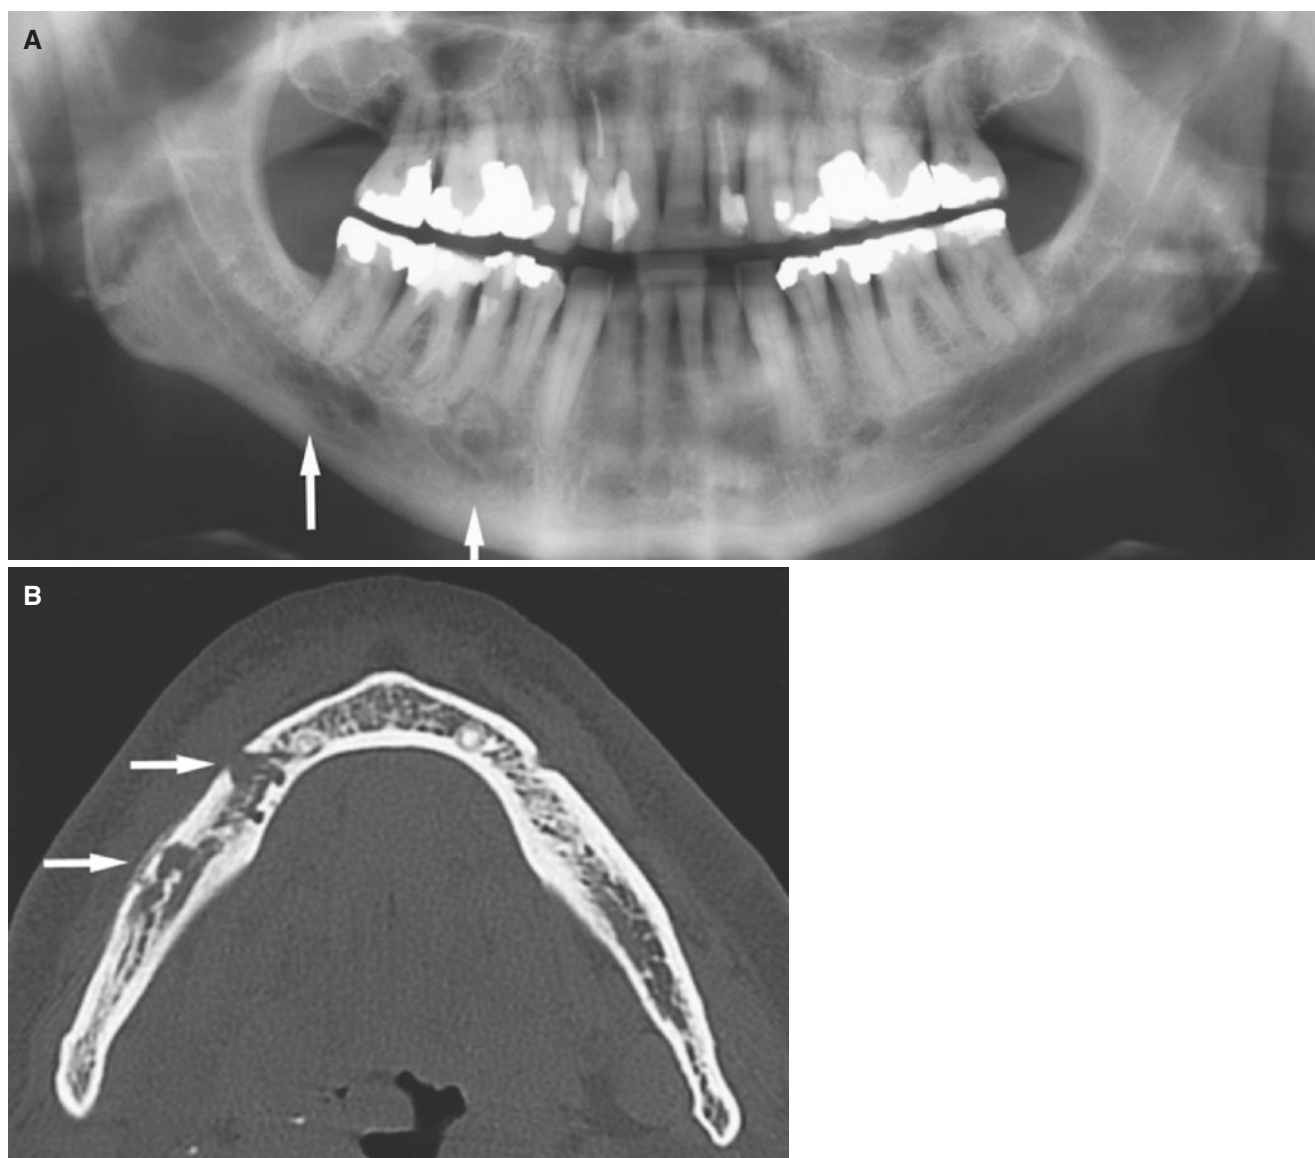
Osteomyelitis, mandible; 58-year-old male with pain and perimandibular swelling. (A) Panoramic view shows diffuse bone destruction caudal to molars (*upper arrow*) and suspected sequestrum caudal to premolars (*arrow*). (B) Axial CT image shows
